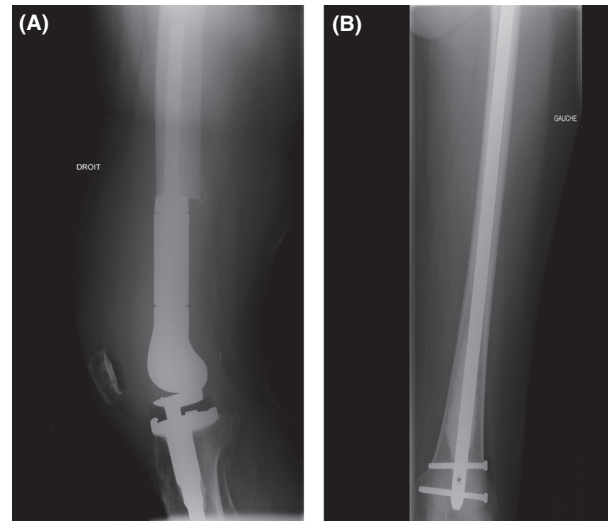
(A) Postoperative AP radiograph of the right femur. (B) Postoperative lateral radiograph of the left femur.
